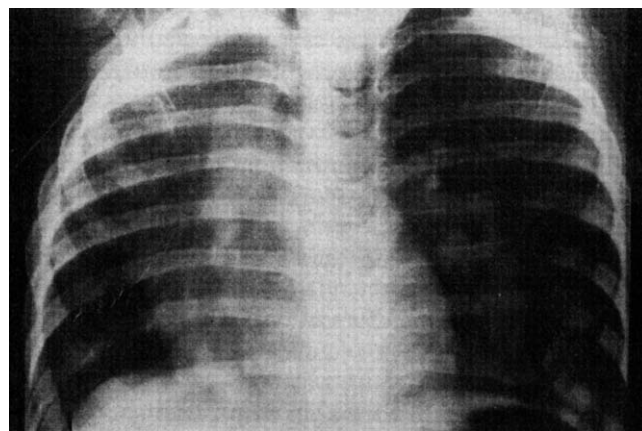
Frontal chest x-ray of a patient with Scimitar vein.
